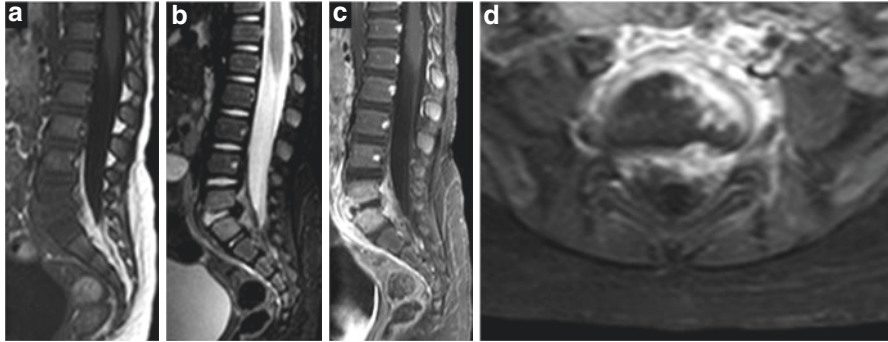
Typical Magnetic Resonance Imaging (MRI) appearance of pyogenic spondylodiscitis. T1-weighted (a), Fat suppressed T2-weighted (b) and GD-enhanced Fat suppressed T1-weighted (c) spine images on the sagittal plane; GD-enhanced Fat-suppressed T1-weighted (d) spine images on the axial plane. MRI shows altered signal, typically hyperintense on T2 weighted fat suppressed image, and diffuse contrast enhancing of marrow of L5 and S1 vertebrae; Hyperintensity and narrowing of the abutting intervertebral disc on the anterior portion, with loss of adjacent endplate definition due to cortical osteolysis. GD-T1w with fat suppression images also reveal enhancing prevertebral and epidural infiltrative phlegmon/abscess
